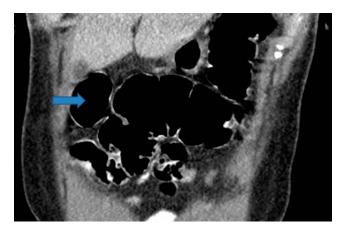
Pelvic and abdominal computed tomography showing gastric diverticulum defined as hypodense lesion (arrow).
